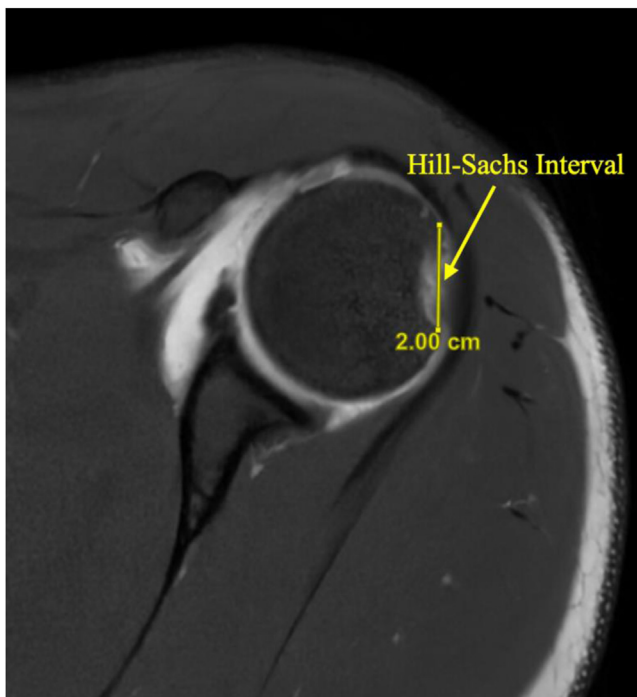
Axial magnetic resonance imaging of a left shoulder with calculation of Hill–Sachs interval (HSI). HSI = width of Hill–Sachs lesion plus width of any intact bone bridge between the lateral margin and rotator cuff insertion.
